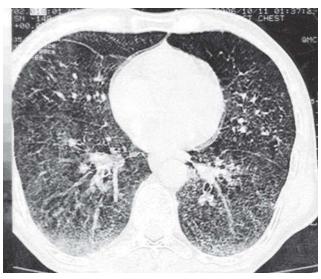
CT thorax (lung window) showing diffuse intra-alveolar opacities of calcific density along with thickening of inter-lobular, peribronchovascular and sub-pleural interstitium.
